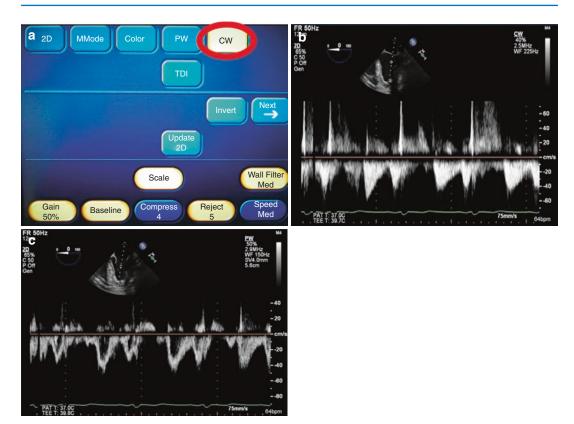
(a) The digital panel indicating the digital button to switch to continuous-wave Doppler imaging (*red circle*). Note similar settings of gain, baseline, and scale at the bottom of the image. (b) An example of continuous-wave Doppler imaging of mitral valve inflow in the midesophageal four-chamber view. Note the "filled-in"
